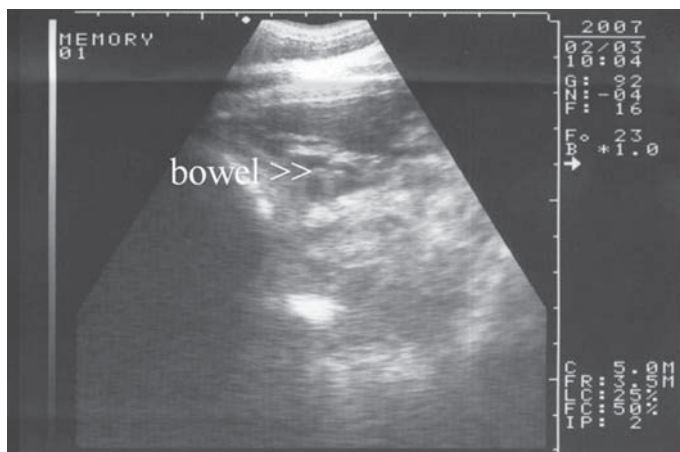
Ultrasonographic view of the left side of the thorax. Notice the bowel segments with liquid contents within the thoracic cavity.
